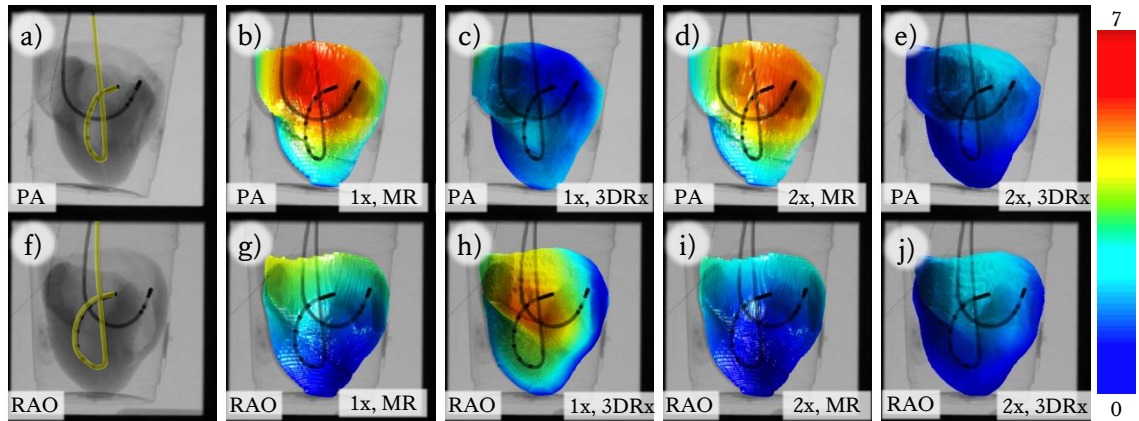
Visual representation of registration results using the b, c, g, h) monoplane 1×BNHC strategy and d, e, i, j) monoplane 2×BNHC strategy applied to the first looped catheter configuration. Colour mapping of the CT data surface rendering shows the spatial distribution of RPD. The data is overlaid onto X-ray in a, b, c, d, e) PA and f, g, h, i, j) RAO 45° views.
